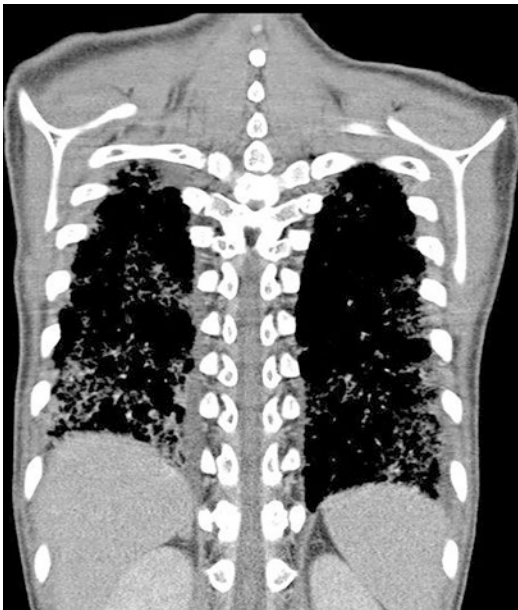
Chest computed tomography showed diffuse, multiple small nodules over bilateral lungs
